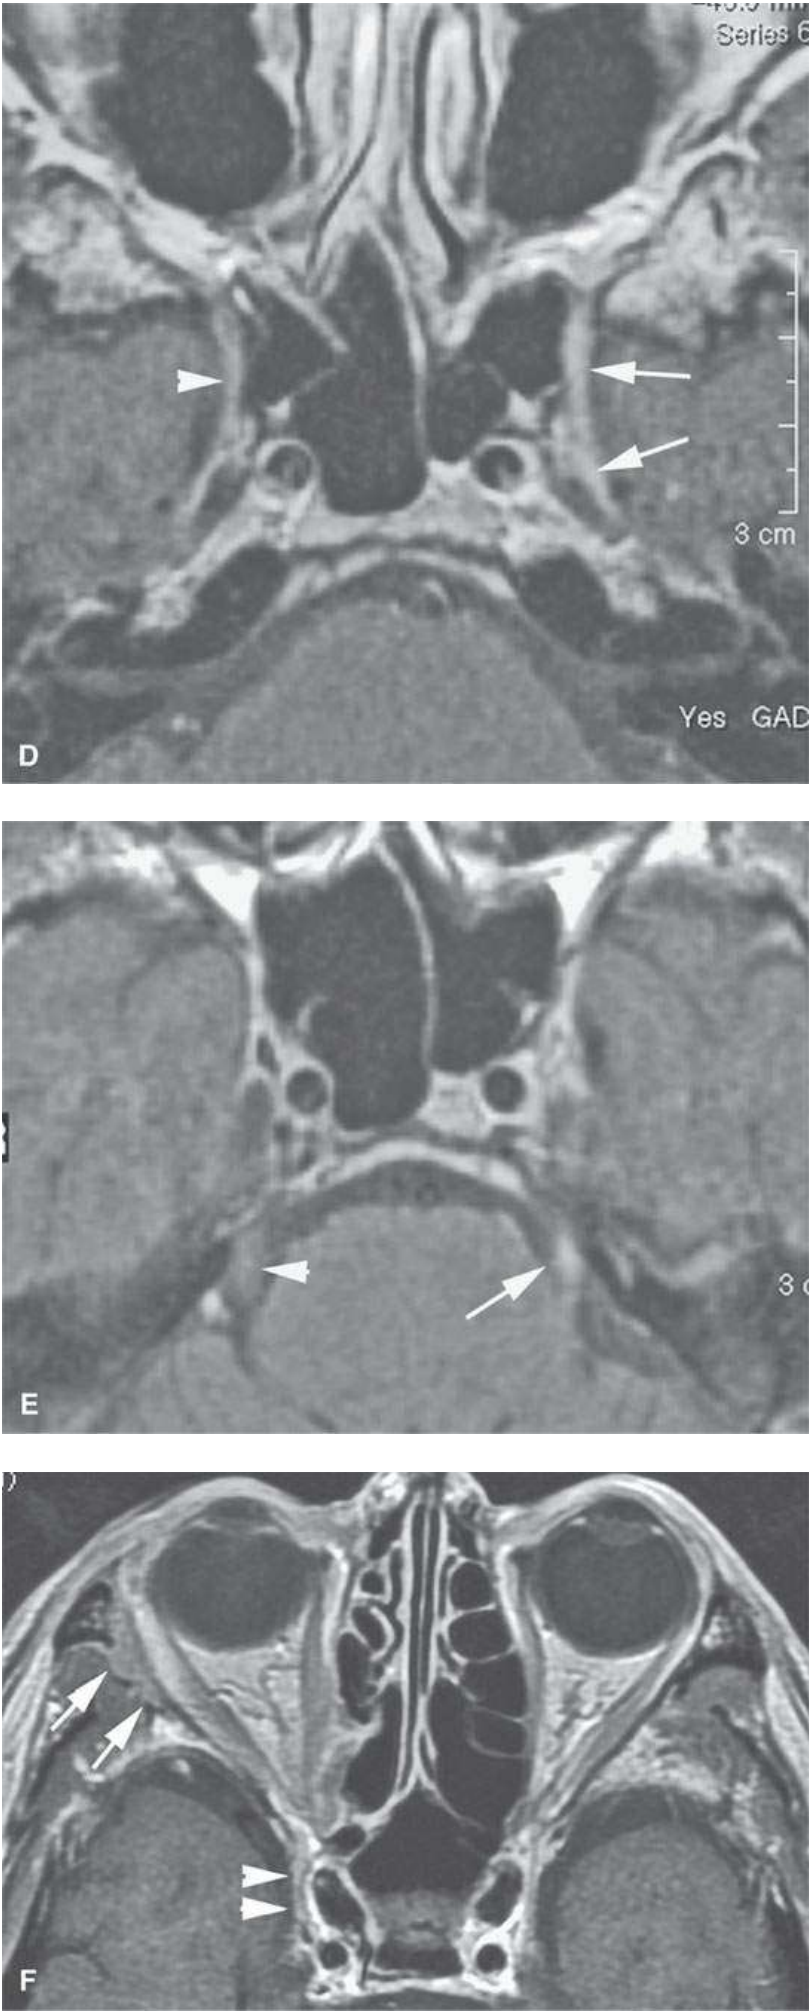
Contrast-enhanced T1-weighted (T1W) magnetic resonance imaging (MRI) of a patient with perineural spread of squamous cell carcinoma (SCCA) of the nasolabial fold region along the second division of the trigeminal nerve to the trigeminal nerve cisternal segment; the involved nerve is enlarged and enhances abnormally (*arrows*) compared to the normal nerve (*arrowheads*) in all of its segments (A–E). F: Contrast-enhanced T1W MRI of another patient with perineural spread of facial skin SCCA along the frontozygomatic branch of V2 (*arrows*) and the foramen rotundum (*arrowheads*).
